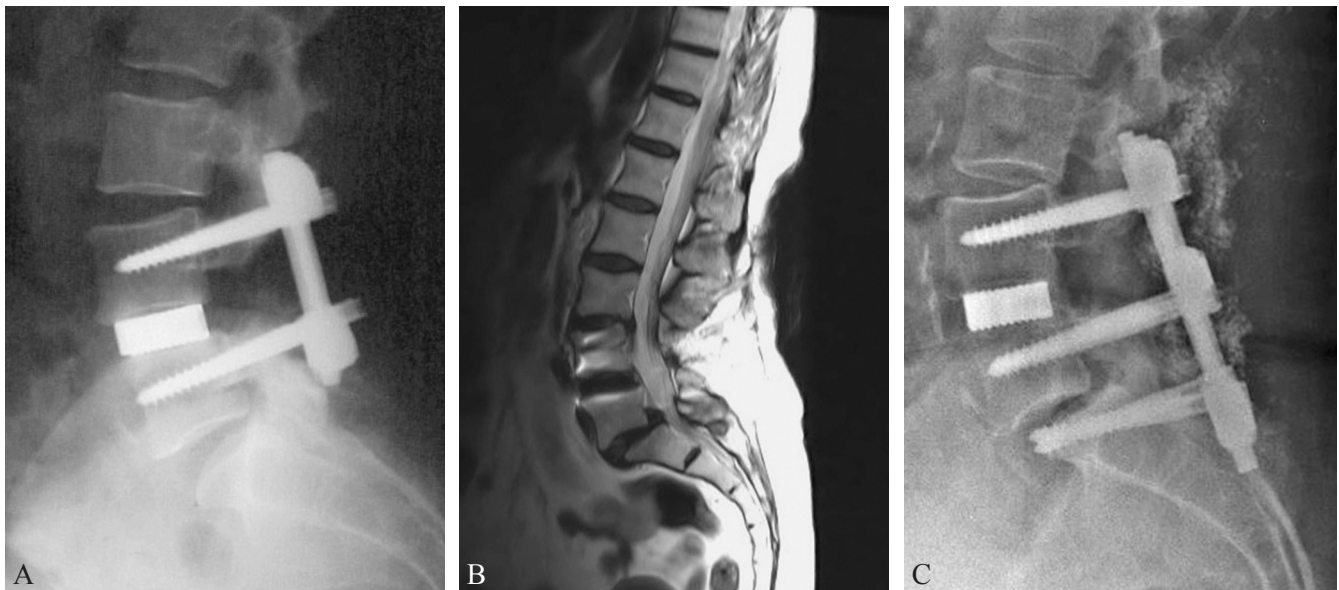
A 66-year-old woman previously underwent L4-L5 PLIF for the treatment of degenerative spondylolisthesis: 8 years after the first surgery she developed symptomatic L5-S1 spondylolisthesis. Control lateral radiography after the first surgery showing L4-L5 PLIF (A). T2-weighted magnetic resonance imaging of the lumbar spine demonstrating adjacent segment degeneration at L5-S1, with grade I spondylolisthesis. She underwent fusion extension to S1. Immediate postoperative lateral radiography showing L4-S1 fusion (C).
